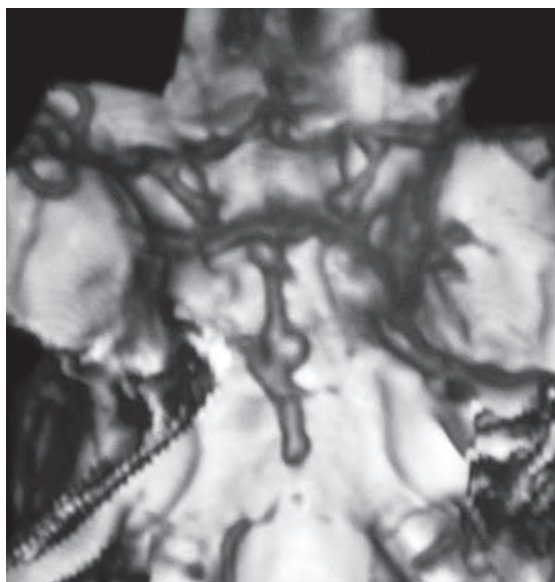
CT angiography with three-dimensional reconstruction showing mid-basilar artery aneurysm
